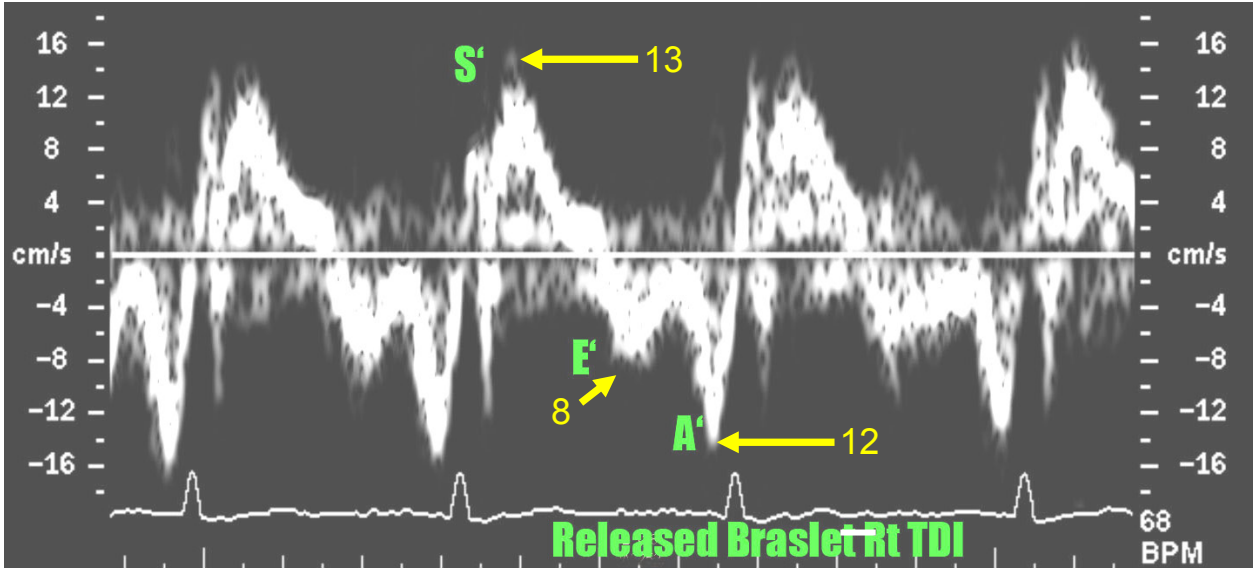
Echocardiographic tissue Doppler image of the right ventricular free wall from on orbit approximately 8 beats after the Braslet was released.
